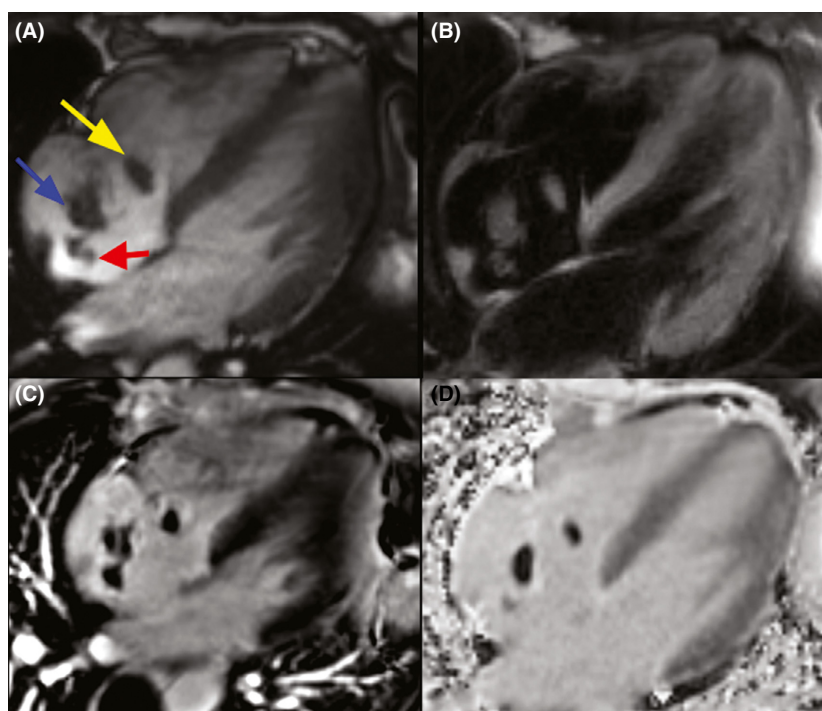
MRI characterization of right atrial thrombi. (A) A four-chamber Steady-State Free Precession (SSFP) cine shows three separate right atrial thrombi. There is thrombus associated with a catheter tip (red arrow). The largest thrombus is noted in the mid-portion of the right atrium (blue arrow). Thrombus is also noted close to tricuspid valve (yellow arrow). (B) A four-chamber fat-suppressed double inversion recovery image excludes lipoma as an explanation for the mass. (C) A 4-chamber perfusion image more clearly demonstrates low uptake of contrast compared to the blood pool. (D) Phase-sensitive inversion recovery imaging shows minimal late gadolinium enhancement when compared to normal myocardium. These cardiac MRI findings are consistent with intracardiac thrombus and are not typical of myxoma or vegetation.
